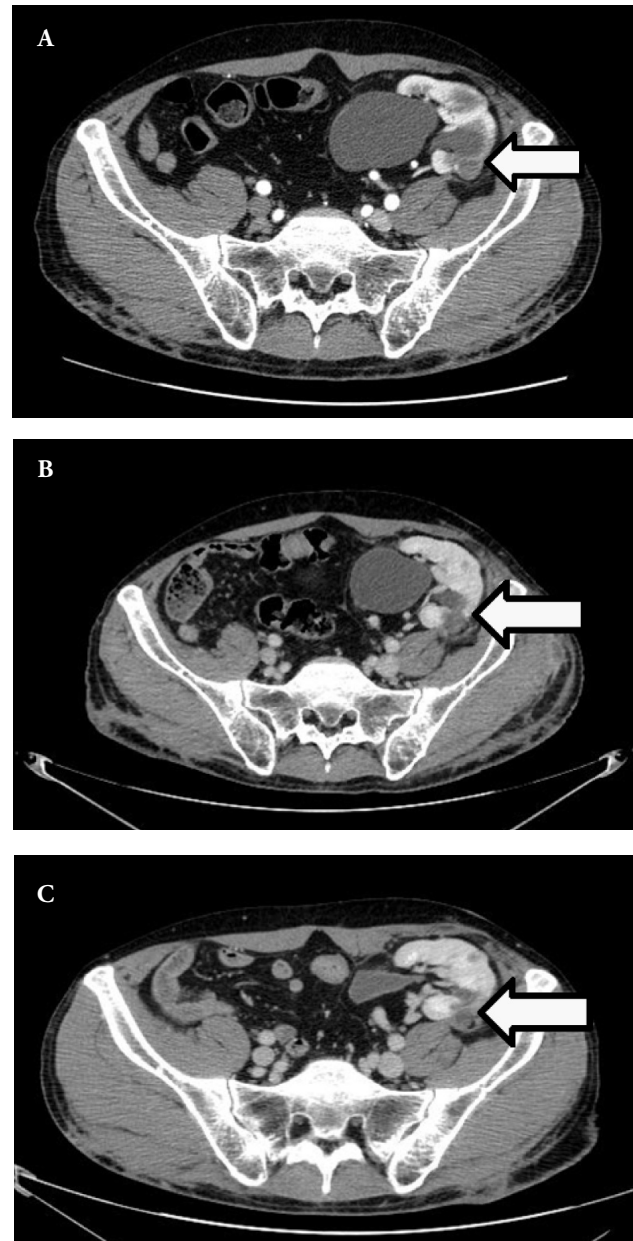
A – CT scan before RFA, B – CT scan 6 months after RFA, C – CT scan 12 months after RFA
